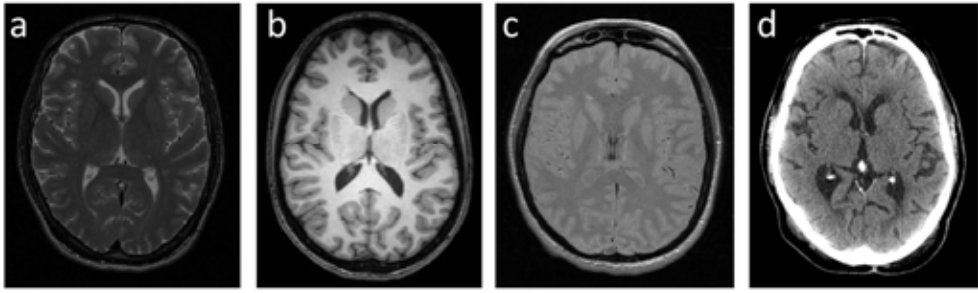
MRI and CT images of the brain. a) T2-weighted MRI b) T1-weighted MRI c) Proton density weighted MRI (Courtesy of Unit of Functional Neurosurgery, Queen Square , London) d) CT.
